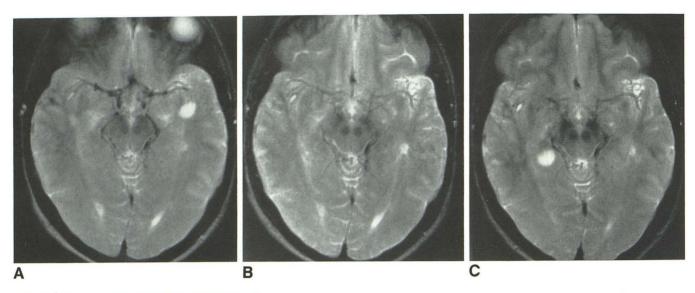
MR images (TR = 2000 msec, TE = 90 msec).
